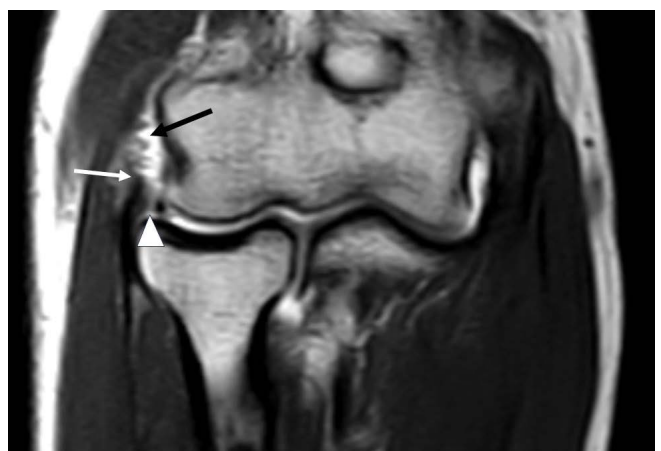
Coronal T1-weighted image: complete tear of the RCL (white arrow), complete tear of the meniscus homologous (arrowhead) and torn insertion of the common extensor tendon (black arrow).
